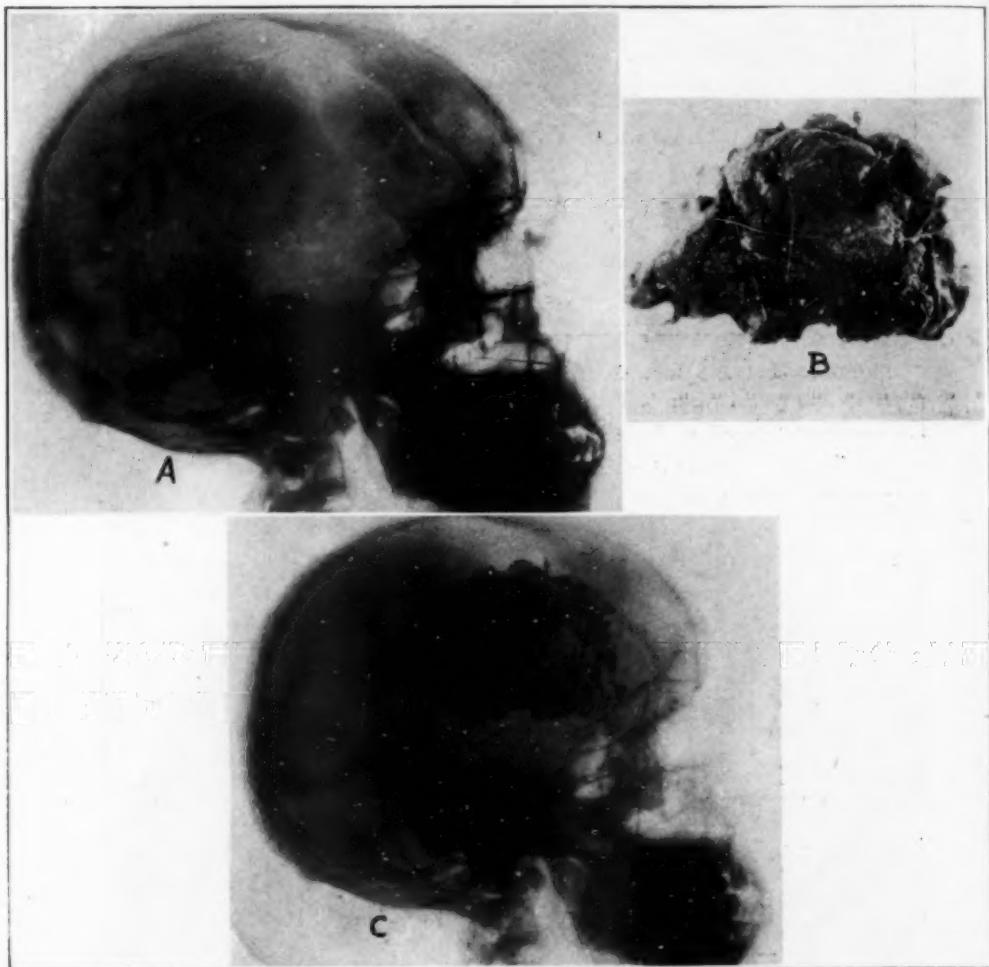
Endothelioma of right frontal and parietal lobes. *A*, roentgenogram of skull; *B*, the tumor; *C*, the tumor superimposed on the roentgenogram.
